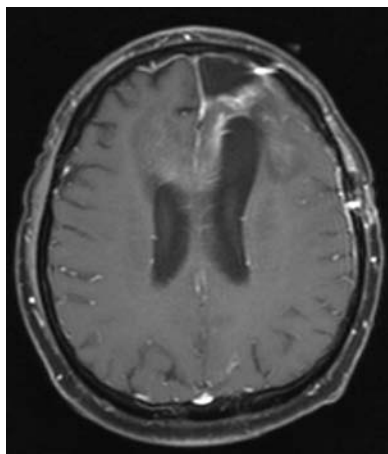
Postradiation, postresection, contrast-enhanced brain MRI of a “butterfly glioma” in a 36-year-old with secondary GTC seizures postoperatively.
